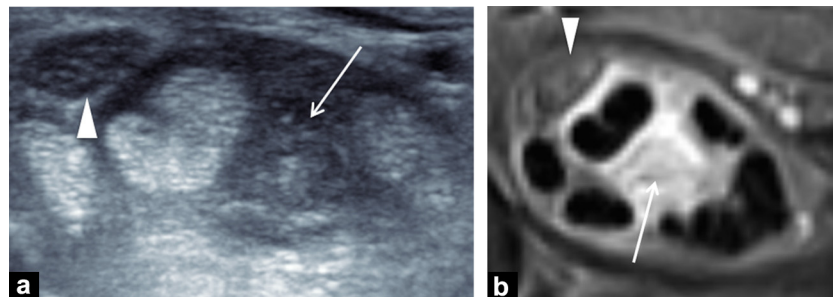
Carpal tunnel syndrome on exertion revealing tenosynovitis of the flexors combined with a compressive mass in the carpal tunnel suggestive of GCT. Pathological anatomy concluded an inflammatory fleshy bud due to non-specific synovitis. a: ultrasound shows hypoechoic thickening of the common superficial flexor tendon sheaths and central hypoechoic mass (white arrow); b: fat-saturated proton density-weighted image in the transverse plane shows a synovial mass (white arrow). The median nerve (arrowhead) shows normal signal intensity.
